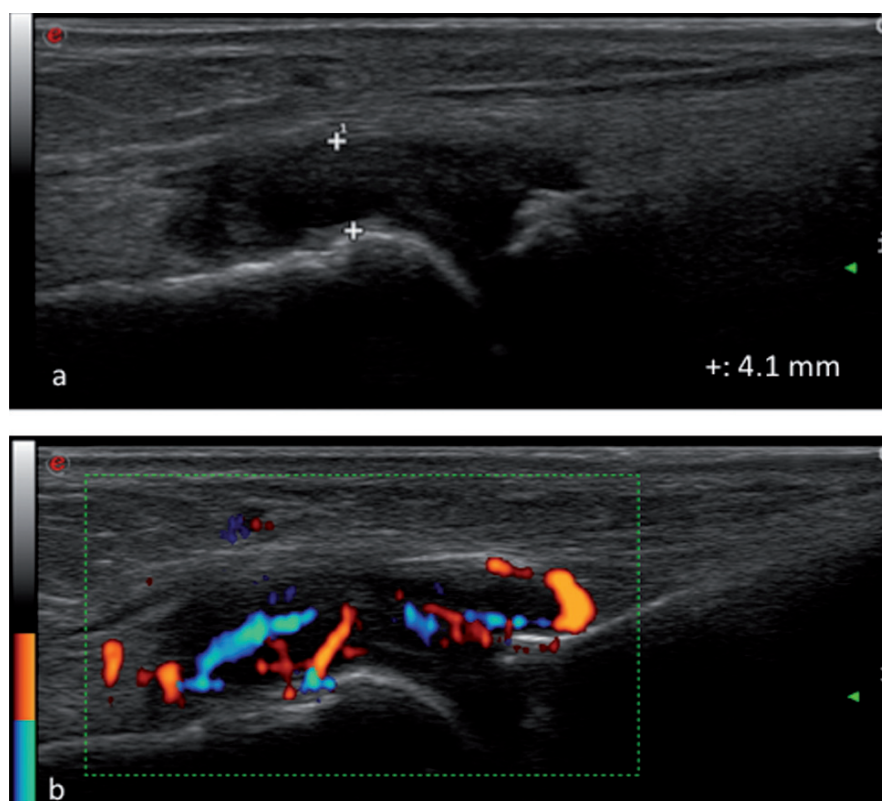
synovitis of the MTP joint 2 at dorsal aspect in grey scale ultrasound (a), grade 3 and in power Doppler ultrasound (b), grade 2.
